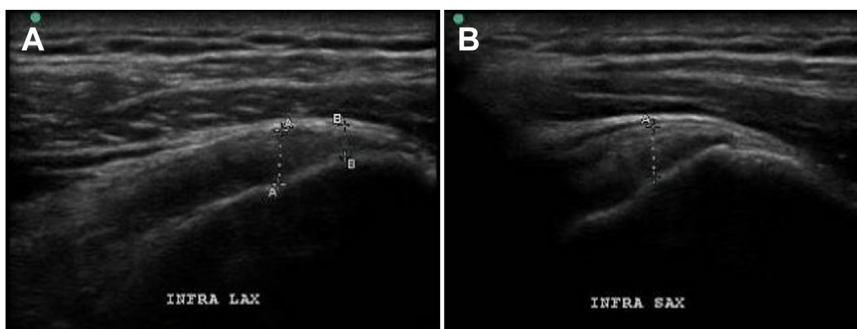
(A and B) Ultrasound (US) images of the infraspinatus from Case 1. (A) US images of the infraspinatus long-axis measurement view from Case 1. (B) US images of the infraspinatus short-axis measurement view from Case 1.
